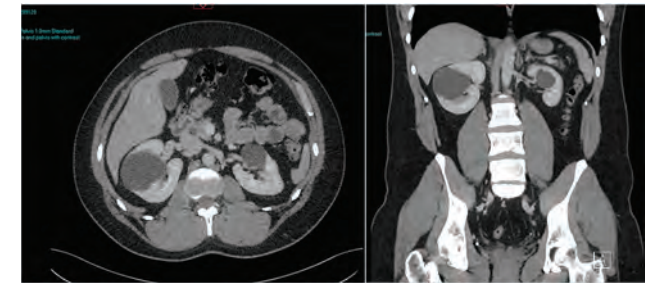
Abdominal CT showing few large kidney cysts
